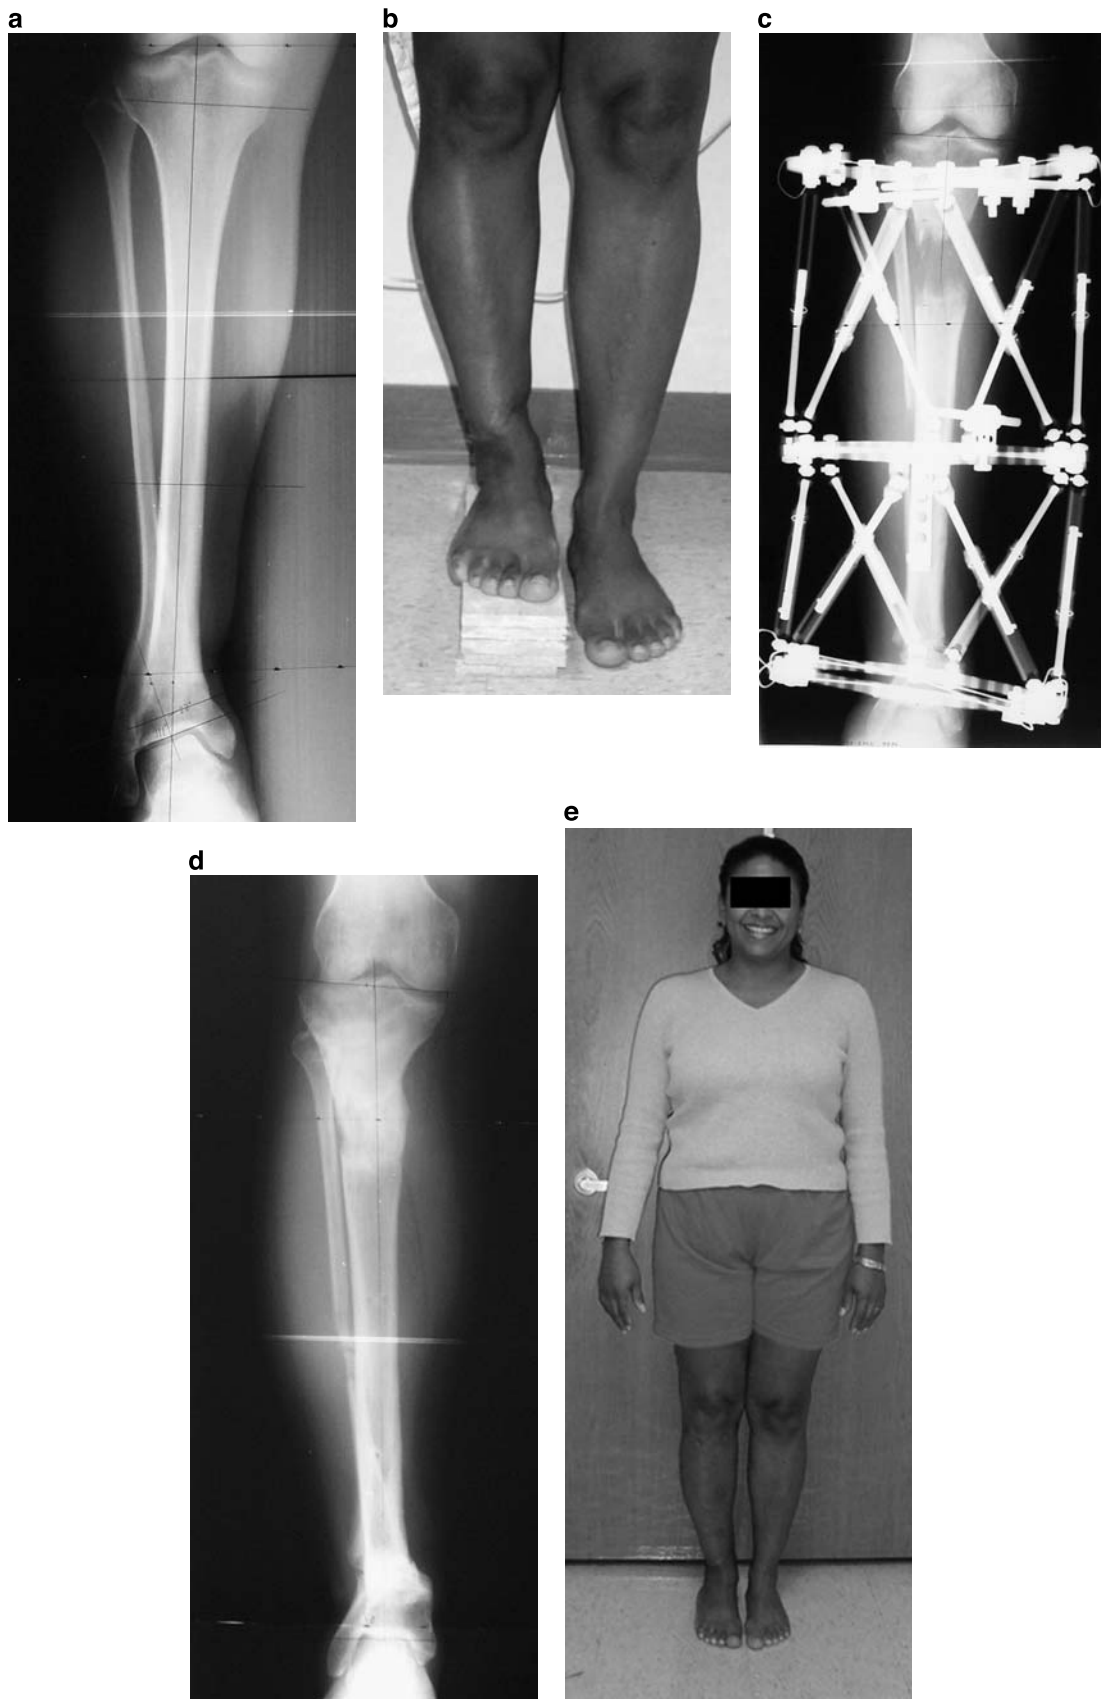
a, b Radiograph and front view of a patient with a posttraumatic growth arrest. This patient has varus deformity of the distal tibia and 6 cm of LLD. c AP x-ray showing a 2-level Ilizarov/Taylor Spatial Frame with proximal tibia lengthening and distal tibia deformity correction. d, e AP x-ray and front view showing successful 2-level lengthening and deformity correction
